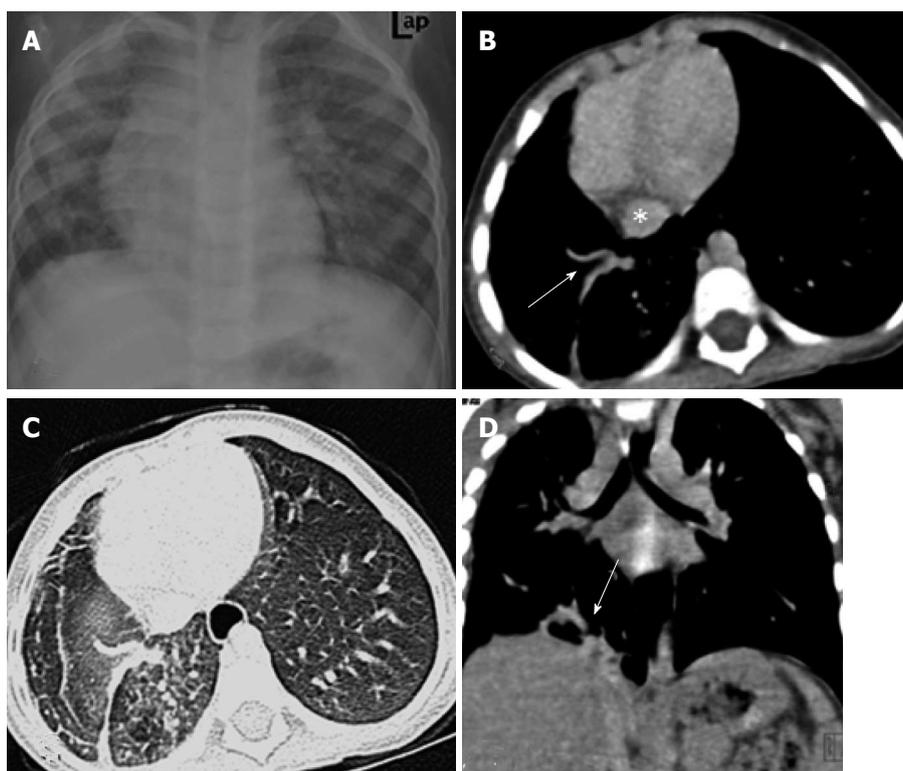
Pulmonary venolobar hypoplasia. Chest radiograph (A) shows volume loss of the right hemithorax with ipsilateral mediastinal shift. Contrast-enhanced computed tomography images (B-D) showing anomalous right inferior pulmonary vein (arrows) coursing inferiorly towards the inferior vena cava (asterisk).
